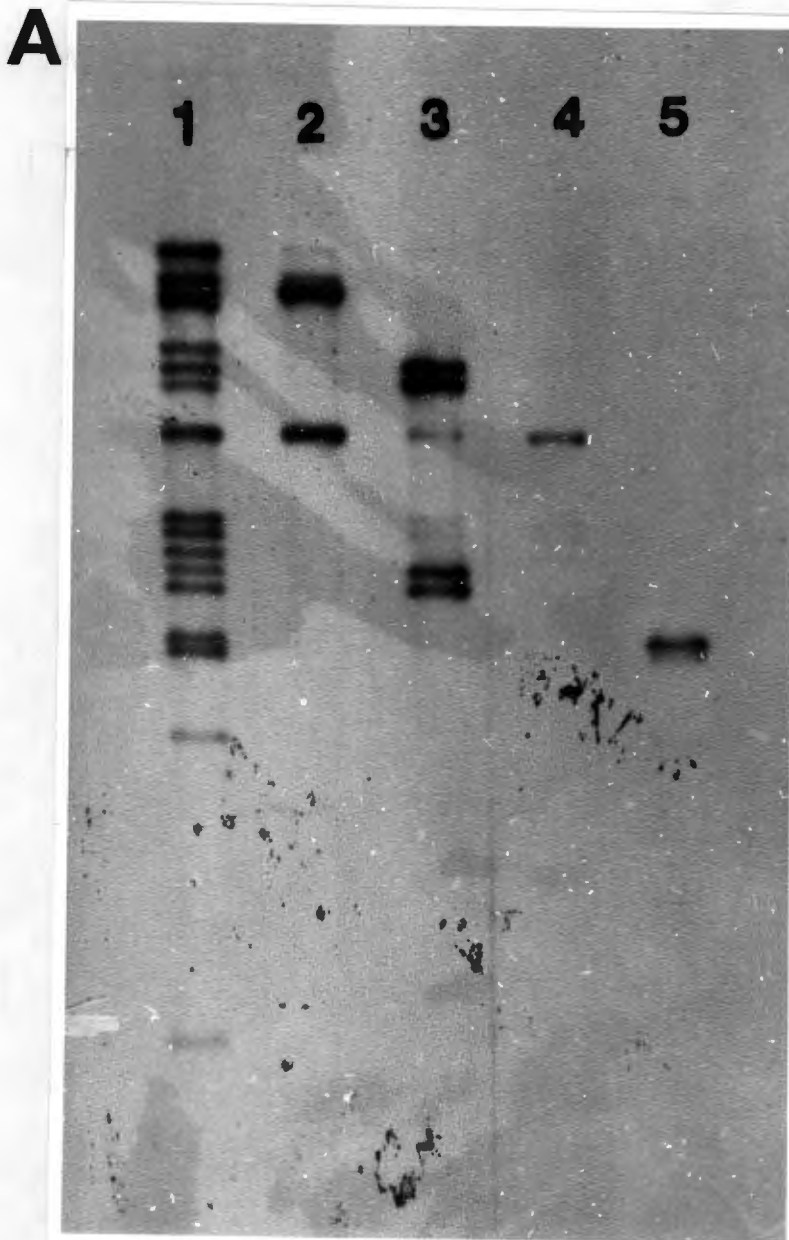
Autoradiographs of Mp Denmark Hind III (A) and Pst I (B) blots that were probed with ^{32}P -labelled Mp Benin Pst I fragments. Lanes 1 - 5. 1: Mp Benin Pst I whole genome; 2: Pst I B; 3: Pst I F+G; 4: Pst I H; 5: Pst I L. The same probes were used for both blots. X-ray film exposed overnight.
